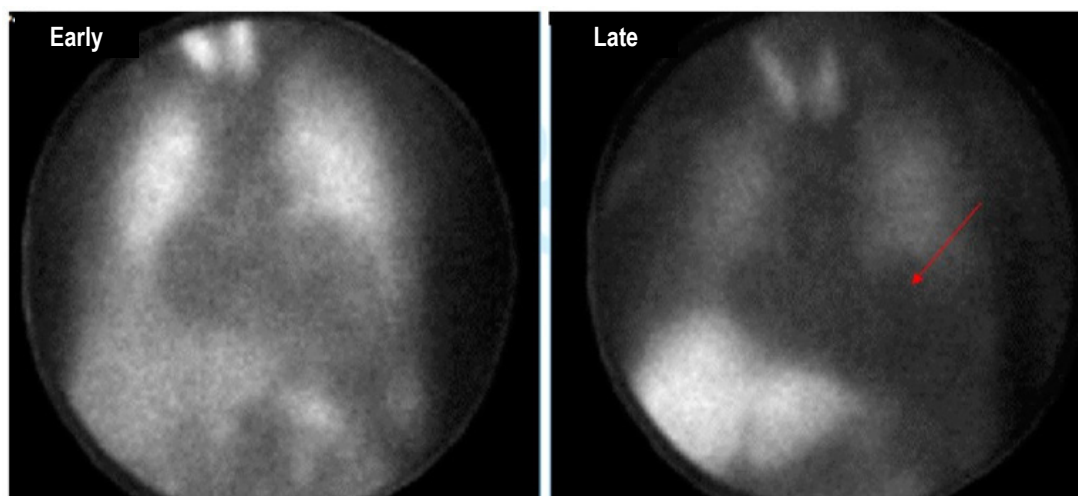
Abnormal cardiac scintigraphy with MIBG-¹²³I of a patient with advanced heart failure and highly reduced radiopharmaceutical uptake in the cardiac area (arrow), which denotes cardiac sympathetic hyperactivity. Black and white images of the anterior thorax, acquired approximately 15 minutes (early) and 4 hours (late) following intravenous injection of the radiopharmaceutical MIBG-¹²³I.
